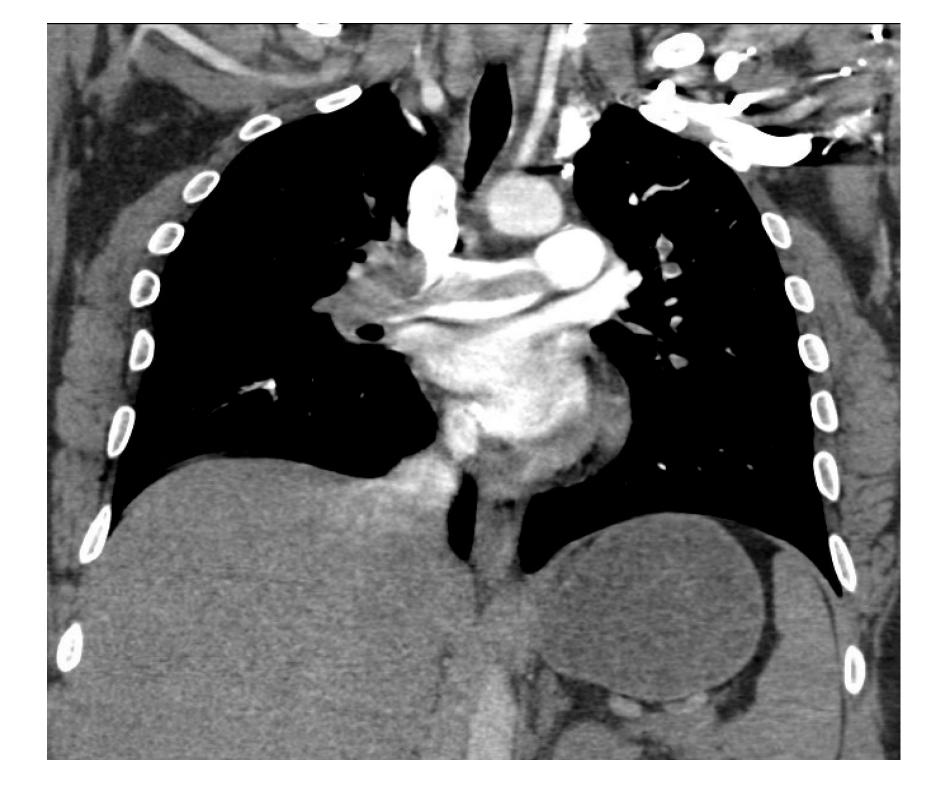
CTA Sagittal view showing saddle PE
